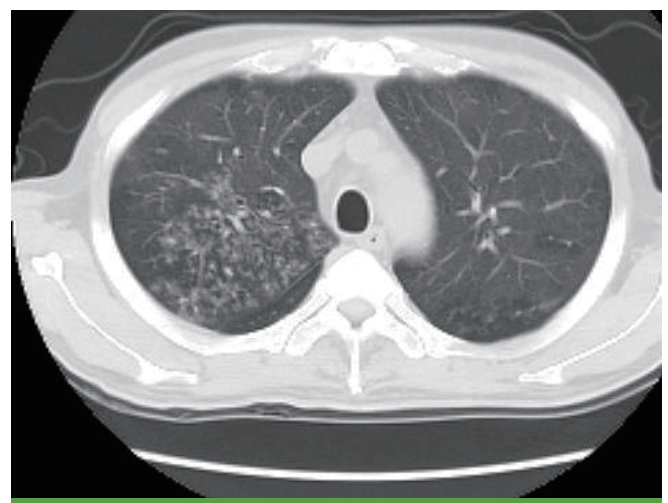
The chest CT scan at the second admission shows multifocal clusters of the ill defined small centrilobular nodular opacities with bronchial/bronchiolar wall thickening and linear branching opacities in both lungs.
